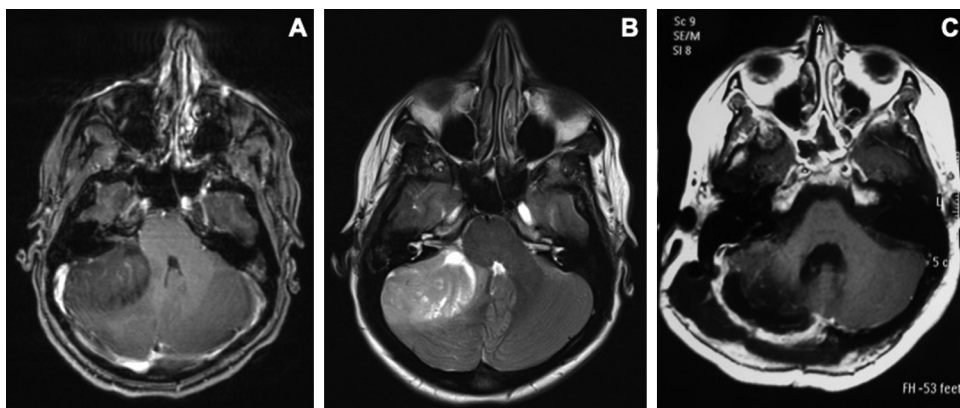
MRI: (A) T1 W contrast-enhanced axial; (B) T2 axial; (C) Postoperative T1 W gadolinium-enhanced axial.
